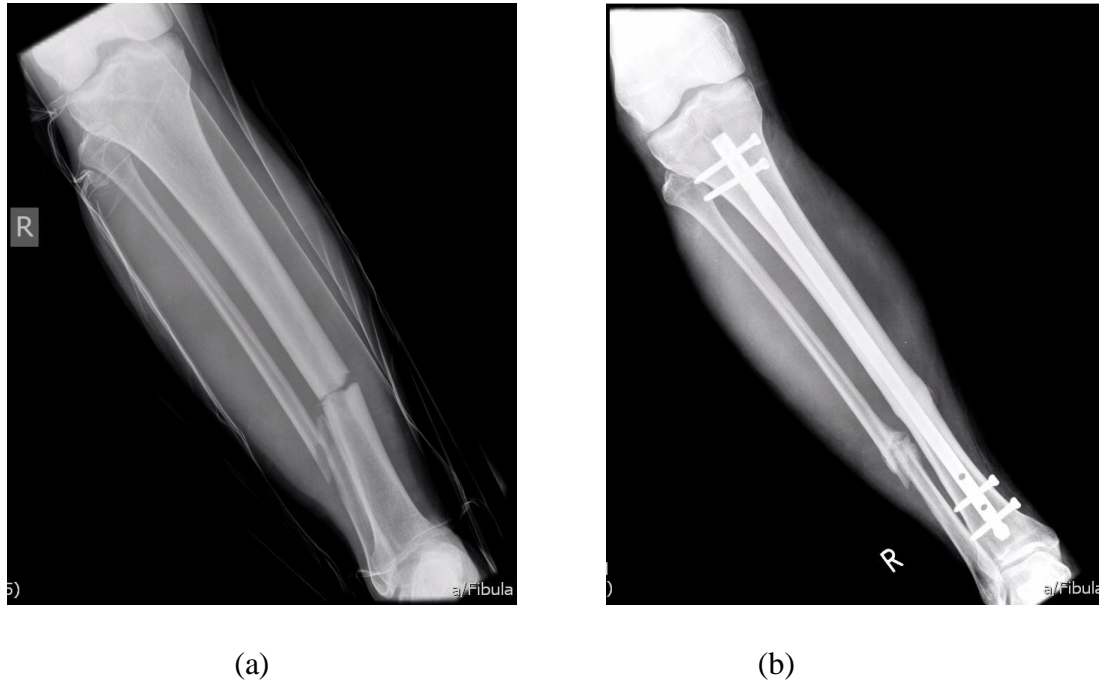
(a) and (b): Oblique x-ray images of osteopenic patient on day 1 of presentation of fracture
